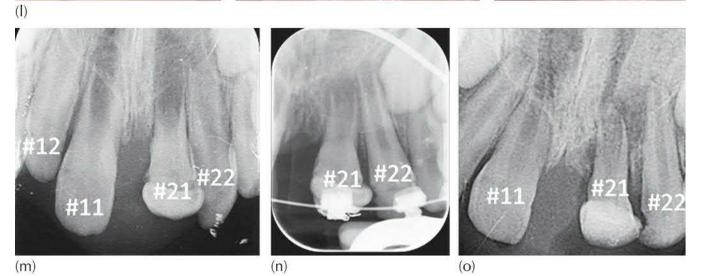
(a) A periapical radiograph showing partially completed crown development of the four incisors and the beginnings of lingual dilaceration of the left central incisor. Note the complete
